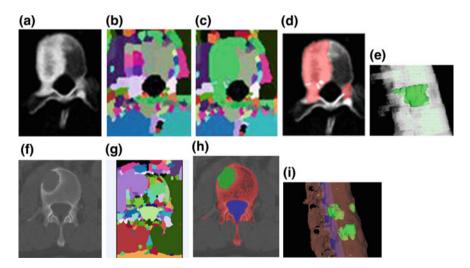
Candidate detection and segmentation. \mathbf{a} CT image of a vertebra with sclerotic lesions; \mathbf{b} watershed result; \mathbf{c} graph cut result after watershed; \mathbf{d} candidate sclerotic lesions; \mathbf{e} 3D segmented sclerotic lesions; \mathbf{f} CT image of a vertebra with lytic lesions; \mathbf{g} watershed result; \mathbf{h} candidate lytic lesions; and \mathbf{i} 3D segmented lytic lesions
